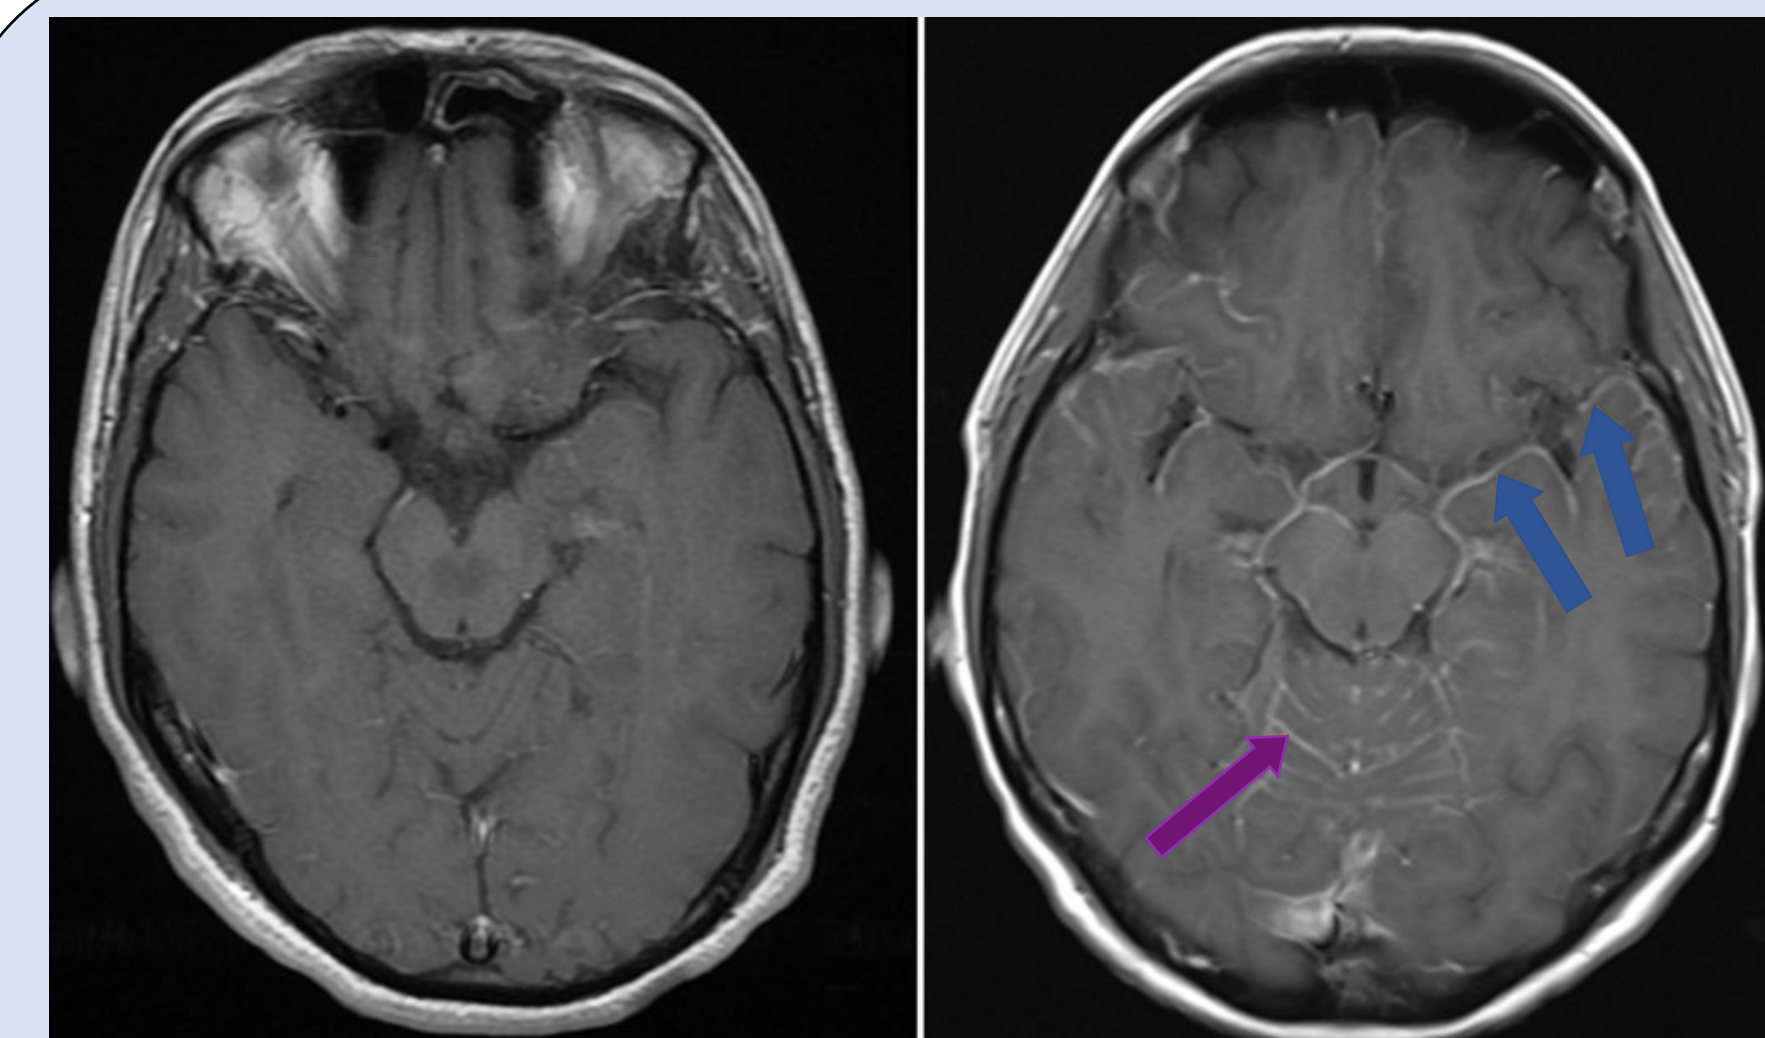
T1-weighted post-contrast images with normal MRI (left) and abnormal MRI (right); Enhancing metastatic disease in meninges of cerebellar folia (purple arrow) and around anterior aspect of L temporal lobe (blue arrow)⁵
